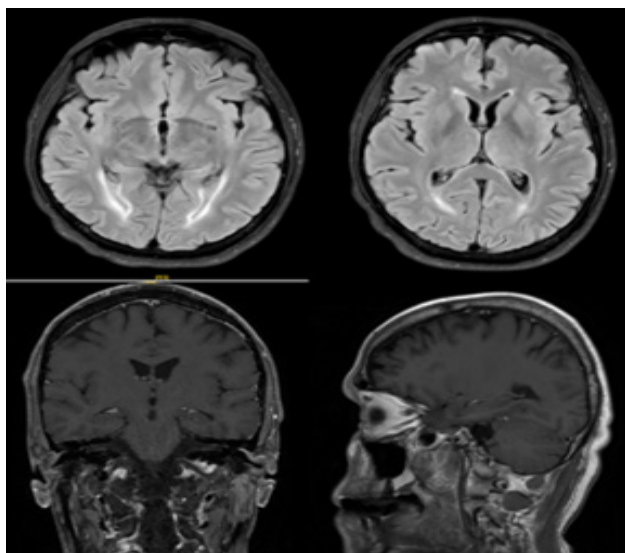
The MRI findings were consistent with ventriculitis and leptomeningeal involvement, including subependymal edema and contrast enhancement on the ependymal surfaces.
